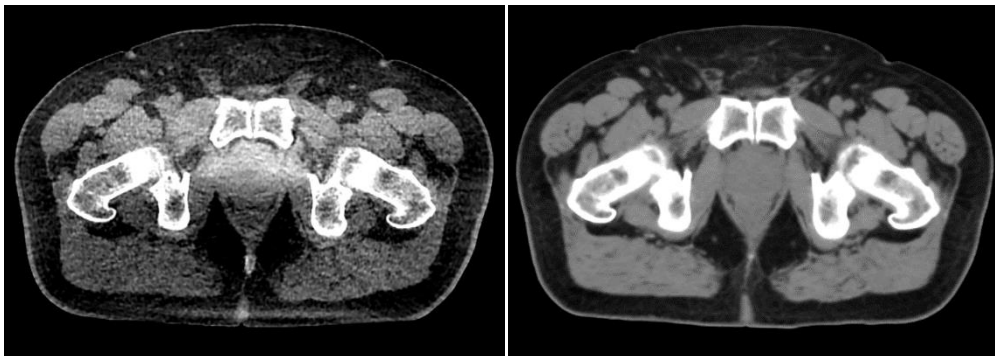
Comparison of image quality in pelvic imaging. Left: conventional Ethos CBCT; Right: sCT generated to match the CBCT anatomy. The sCT is used for the dose computation to overcome the limited image quality of conventional CBCT.
